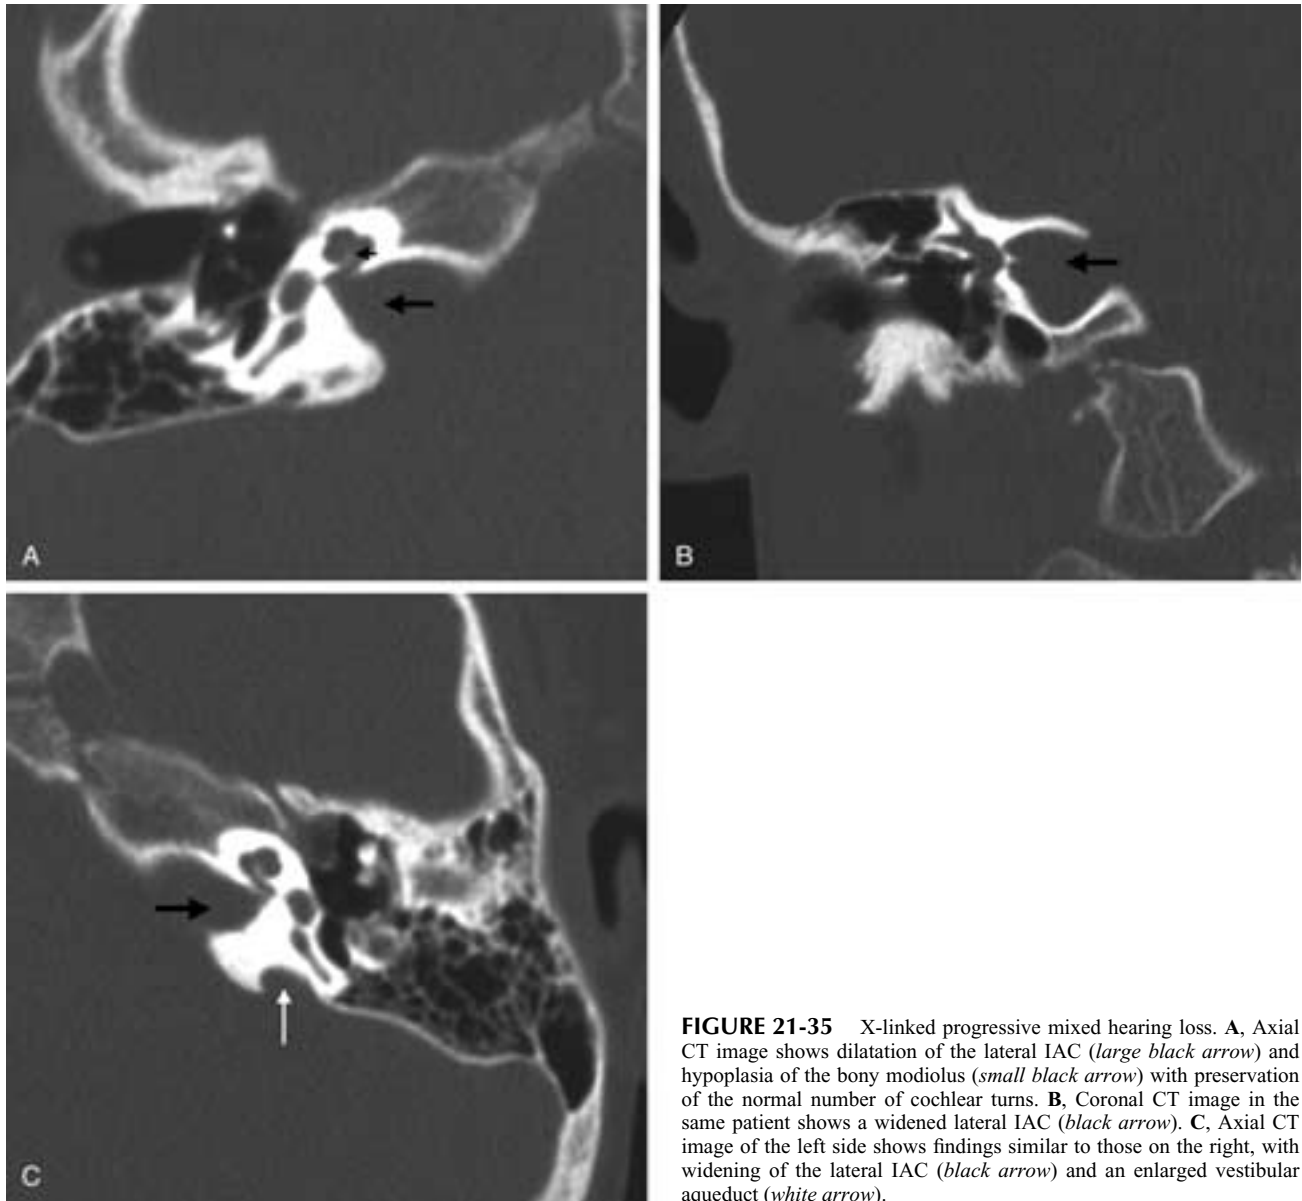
X-linked progressive mixed hearing loss. A, Axial CT image shows dilatation of the lateral IAC (*large black arrow*) and hypoplasia of the bony modiolus (*small black arrow*) with preservation of the normal number of cochlear turns. B, Coronal CT image in the same patient shows a widened lateral IAC (*black arrow*). C, Axial CT image of the left side shows findings similar to those on the right, with widening of the lateral IAC (*black arrow*) and an enlarged vestibular aqueduct (*white arrow*).
